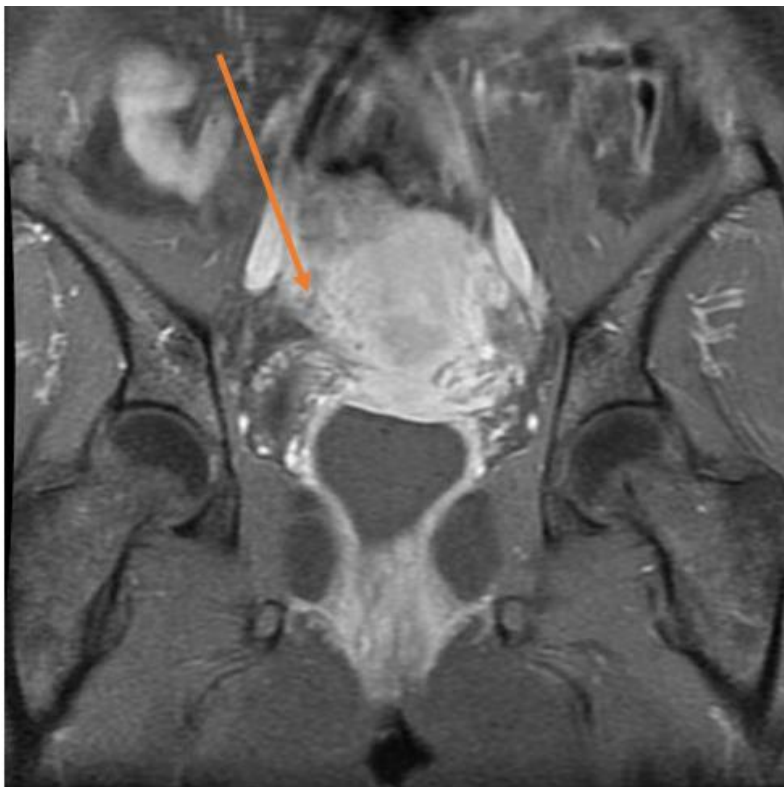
Cervical carcinoma that extends into the parametrium. Coronal pelvis MRI T1 C+fat sat
